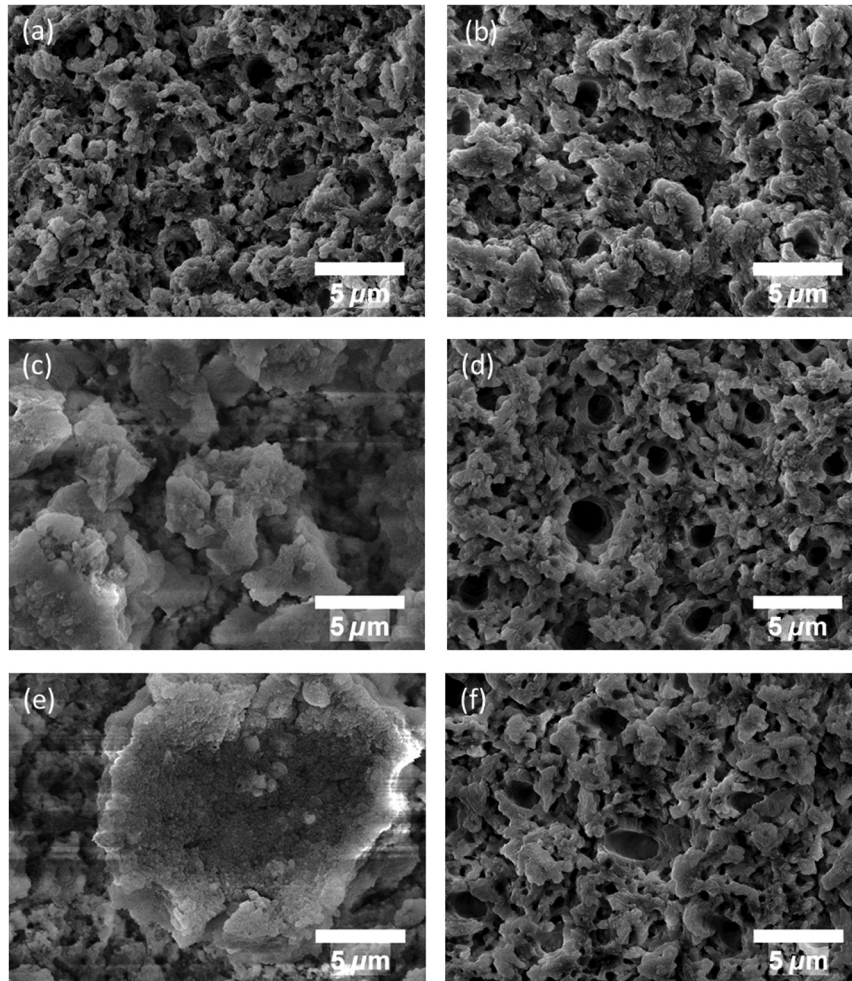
Morphology of laser treated dentin surfaces before and after ultrasonication. Fluences (a) and (b) 2 J/cm^2 , (c) and (d) 7 J/cm^2 , and (e) and (f) 14 J/cm^2 .
